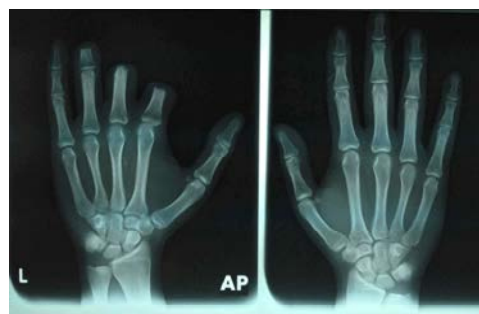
Radiographic examination done at palmar projection showing defect of the index, middle and ring finger of the left hand
